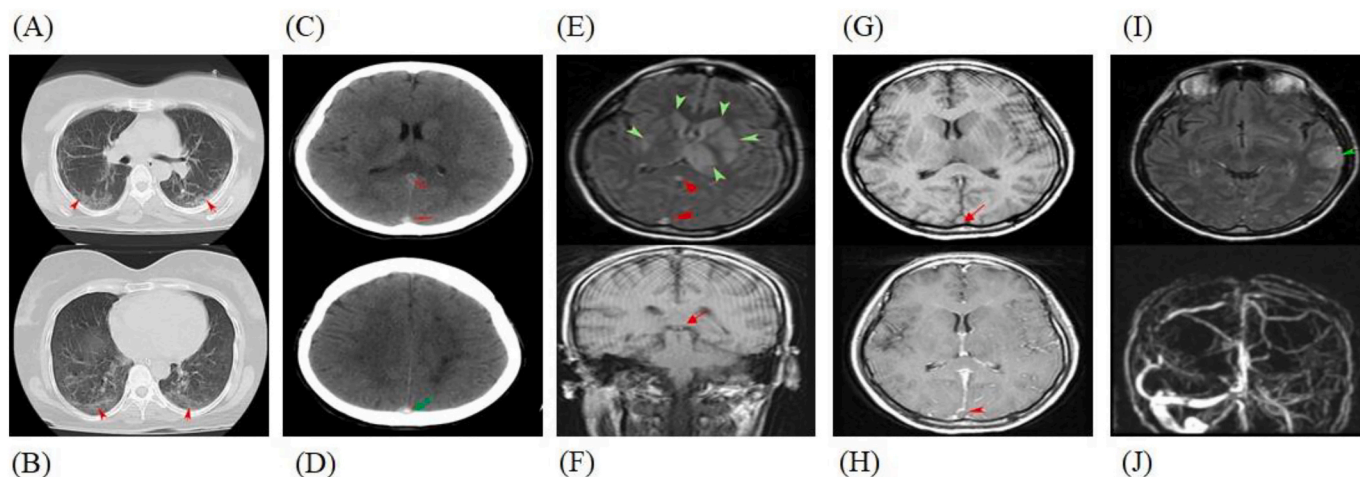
A-B, non-contrast lung CT scan at two cross-sections exhibits multilobar areas of ground-glass opacity (GGO) in the peripheral and subpleural band (red arrowhead) in favor of COVID-19. C-D, non-contrast brain CT scan demonstrates increased density within straight sinus (red arrowhead) and superior sagittal sinus (green arrow). E, axial FLAIR image shows hyperintensity involving the bilateral thalami (most prominent in the left-side) and bilateral basal ganglia (green arrowhead). Findings were compatible with thrombosis of superior sagittal sinus, straight sinus, both internal cerebral veins and left transverse sinus (red arrowhead). F, coronal T1 weighted image shows hyperintensity at both internal cerebral veins in favor of thrombosis (red arrow). G-H, axial T1 weighted images show lack of signal void at superior sagittal sinus and after GAD injection at the same image, the thrombosis is more visible (red arrowhead). I, hyperintensity at left temporal lobe in favor of venous infarction (green arrowhead), (J) MR venography demonstrates the absence of normal flow-related signal within the deep cerebral veins. (For interpretation of the references to colour in this figure legend, the reader is referred to the web version of this article.)
